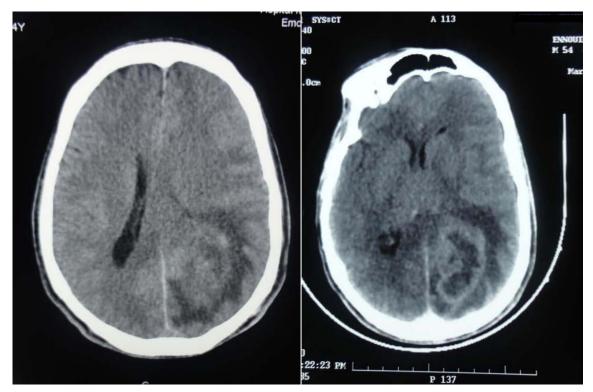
Axial section CT image of a heterogeneous poorly bounded occipital high-grade glial tumor before and after CP injection [17].
